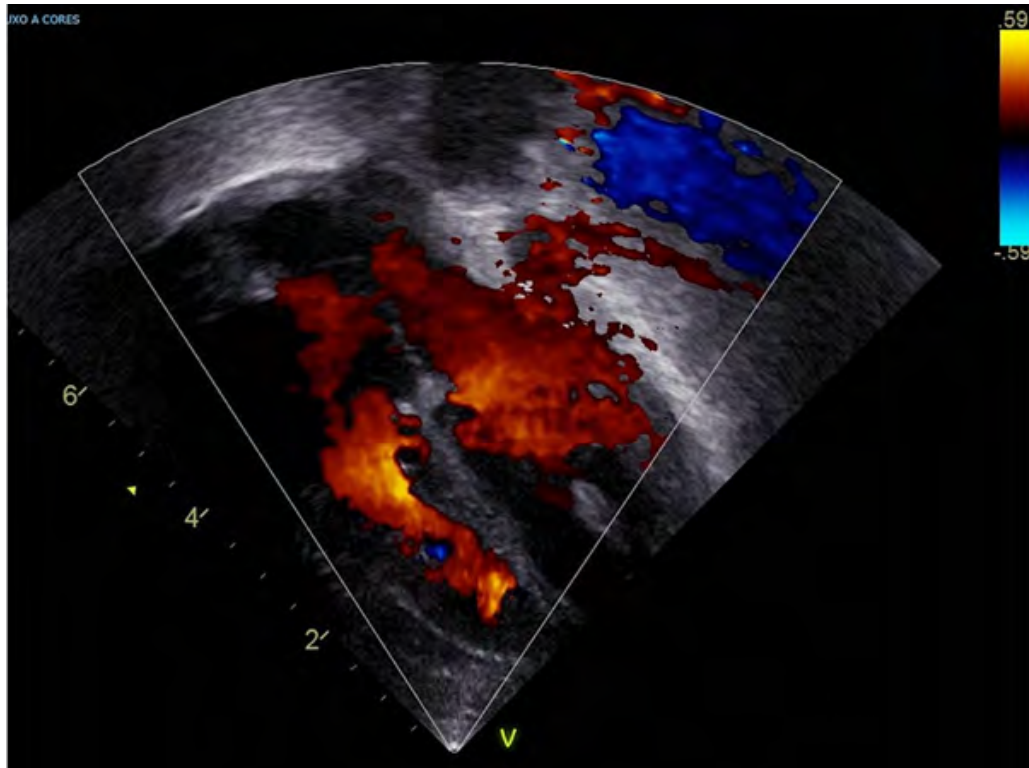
Post-operative echocardiography
